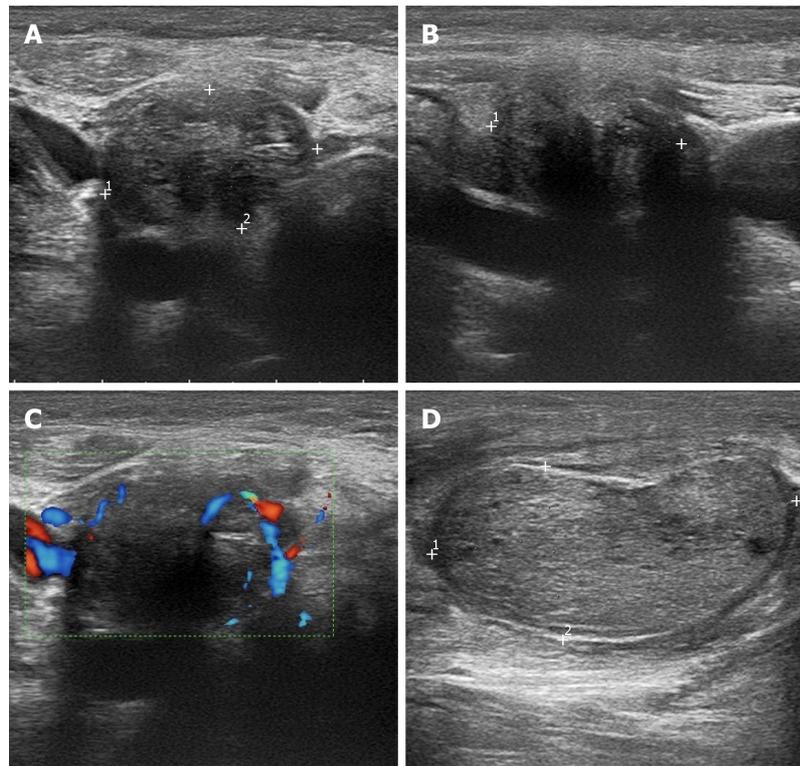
Ultrasound images of calcitonin-negative neuroendocrine tumor with cervical lymph node metastases. A: Cross-sectional image of the thyroid mass with uneven echo; B: Cross-section image of the thyroid gland with the mass invading the thyroid capsule; C: Color Doppler imaging showing abundant blood supply in the mass; D: Swollen cervical lymph node poorly demarcated between cortex and medulla.
